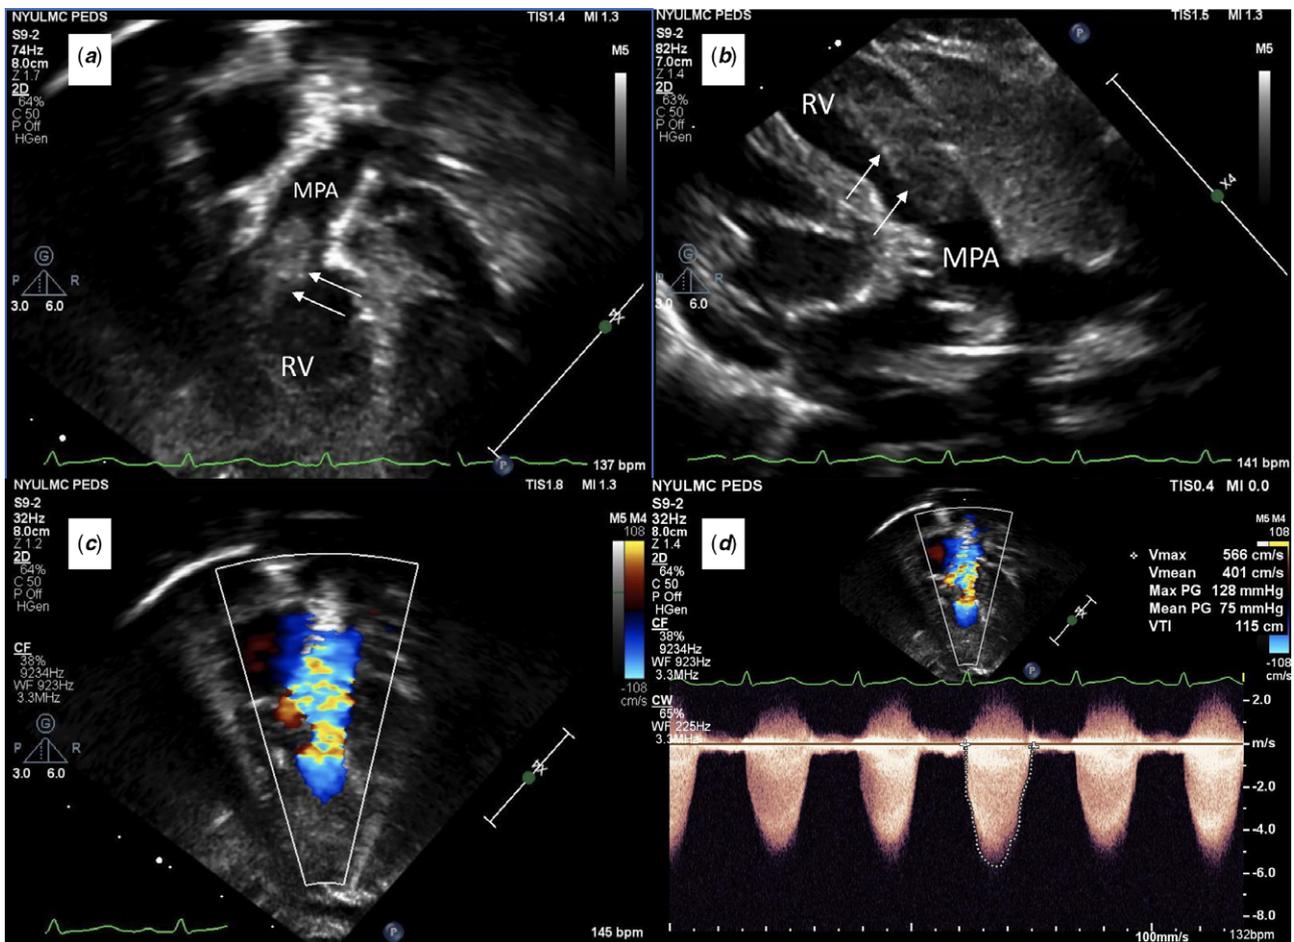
(a): An apical four-chamber view showing the tumour extending from the right ventricle into the right ventricular outflow tract. Arrows point to the tumour. (b): A parasternal long-axis view showing the tumour extending into the right ventricular free wall. Arrows point to the tumour. (c): An apical four-chamber view with colour flow mapping showing aliasing of flow across the right ventricular outflow tract at the level of the pulmonary valve. (d): Spectral Doppler showing peak gradient of 125 mmHg and mean gradient of 70 mmHg across the right ventricular outflow tract. RV = right ventricle; MPA = main pulmonary artery.
